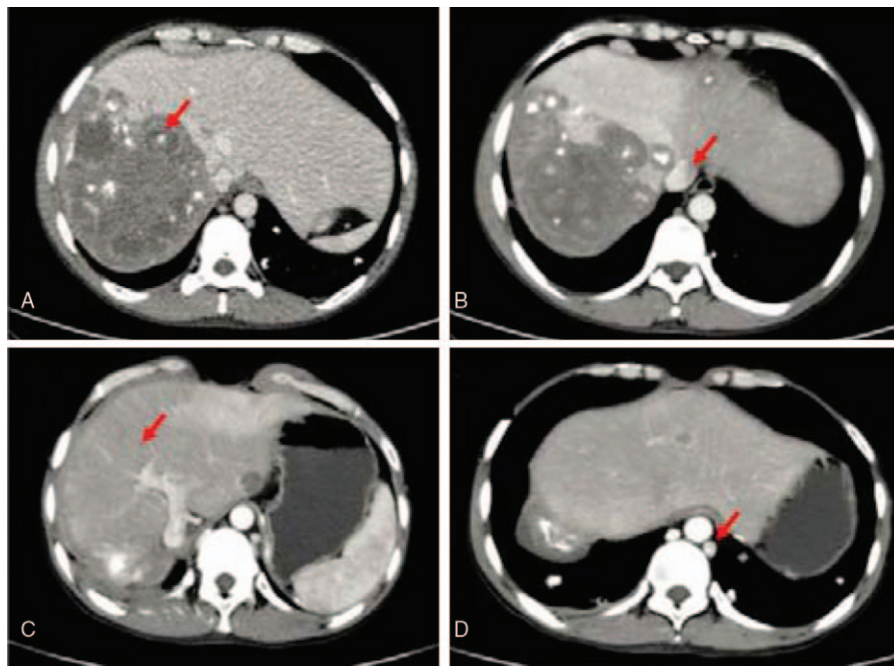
A CT scan of the upper abdomen of an HAE patient. (A) The red arrow shows an alveolar hydatid lesion. (B) The red arrow shows the violations of the IVC. (C) The red arrow shows the left liver after surgery. (D) The red arrow shows an apparently odd vein after surgery. CT = computed tomography, HAE = hepatic alveolar echinococcosis, IVC = inferior vena cava.
